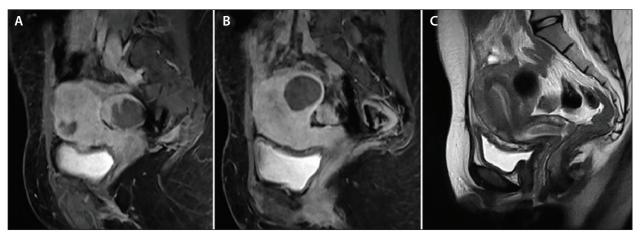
Two sagittal T1-weighted MRIs with contrast (A, B) and a T2-weighted sagittal image (C) demonstrating the two dominant fibroids and the junctional zone.
